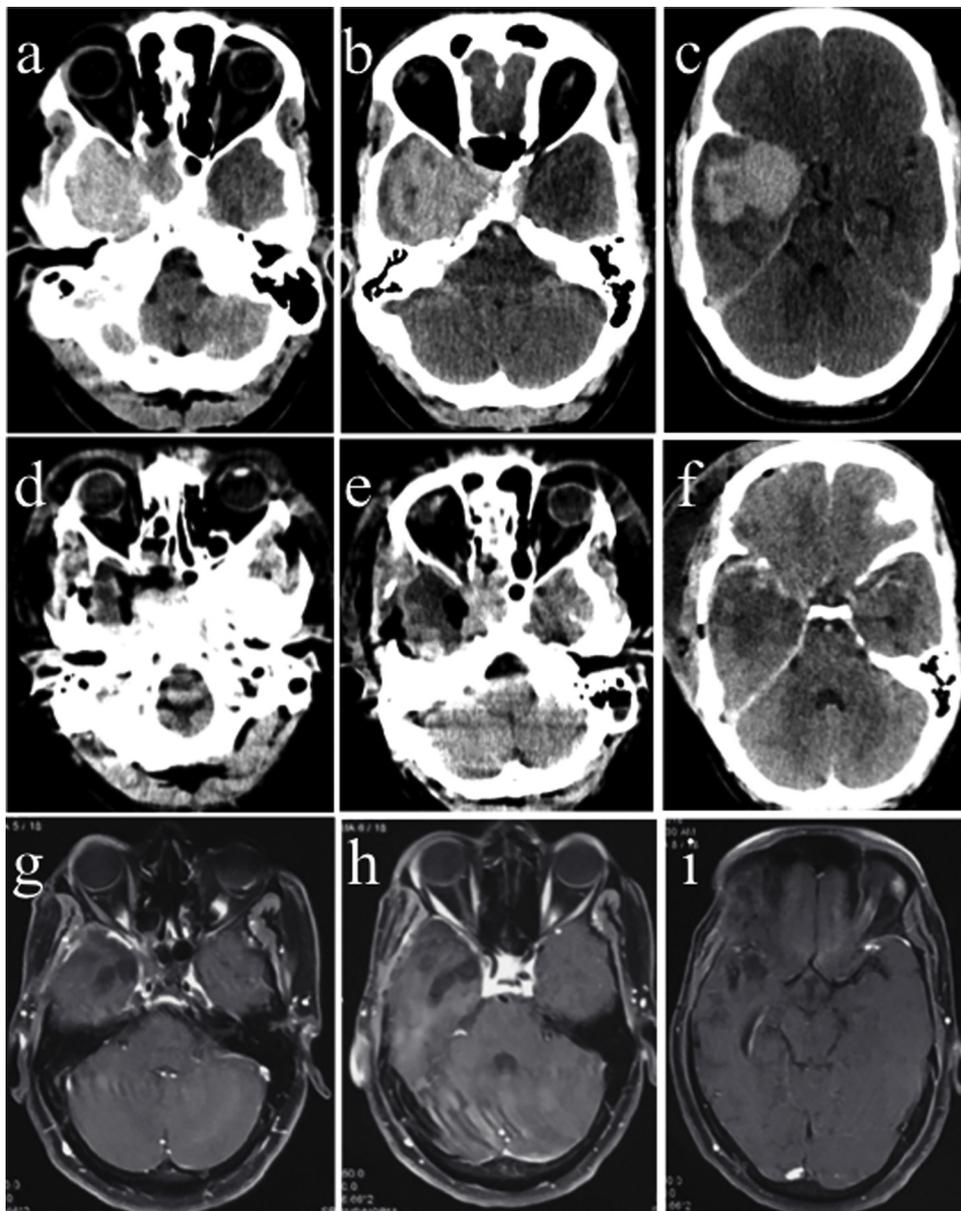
A 28-year-old male patient (no:11 in Table 4) presented with headache and vomiting. Contrast CT scan revealed homogeneously enhancing lesion in right middle cranial fossa with involvement of cavernous sinus and extension into sphenoid sinus (a–c). Patient underwent craniotomy and subtotal excision of the lesion (d–f). Part of lesion involving cavernous sinus and sphenoid sinus was not removed (e). He received liposomal amphotericin and voriconazole. Follow up MRI at one year post surgery reveals complete resolution of the lesion (g–i).
